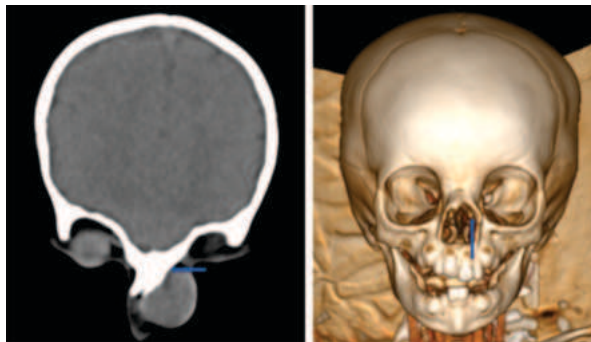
CT Brain Coronal View, 4b VRT Image Of Skull
